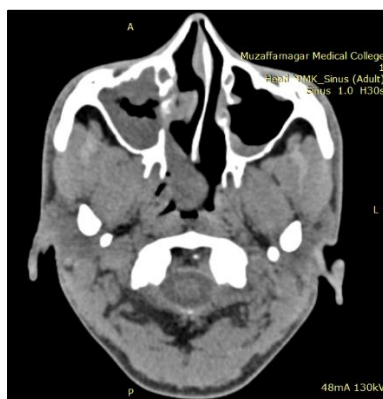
Young female with complain of nasal obstruction and difficulty in breathing through nose. Axial CT showing polypoidal mucosal thickening across right choana & extending posteriorly to nasopharynx without bony erosions, suggestive of antrochoanal polyp.
